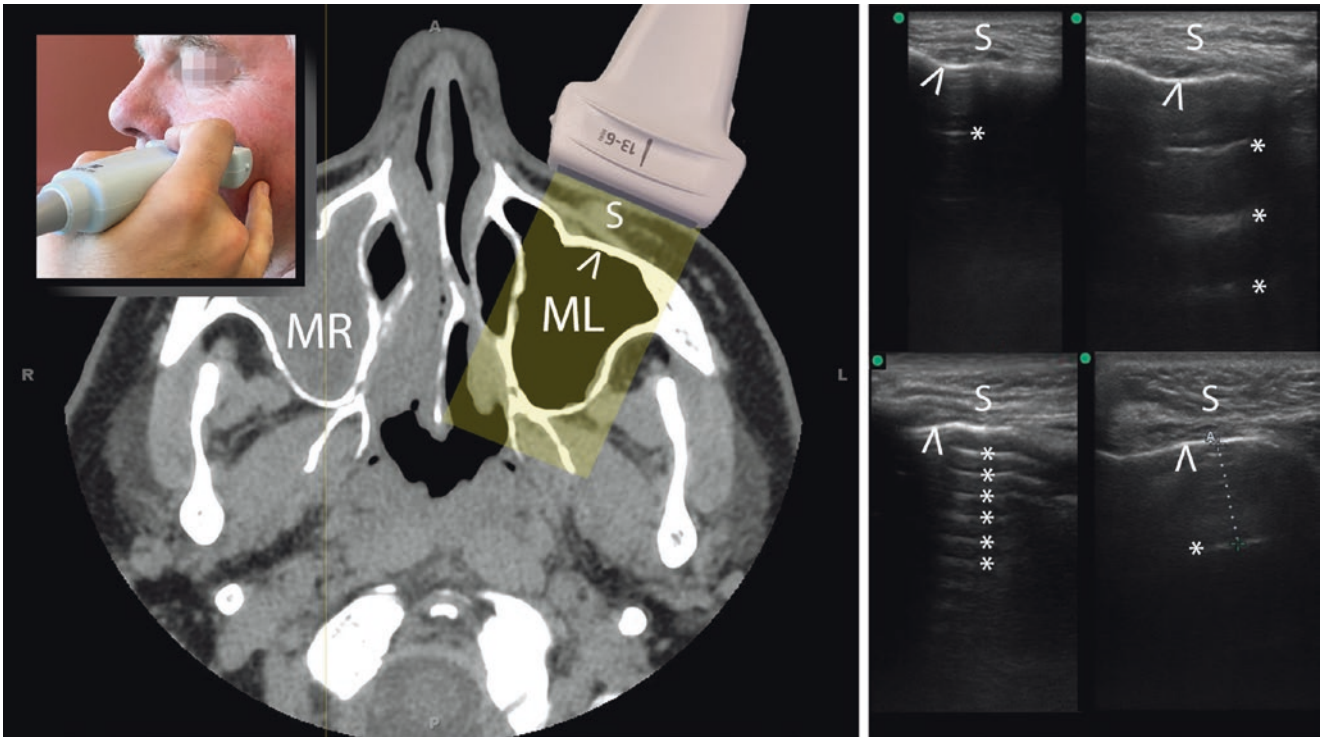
Normal left maxillary sinus (ML) transverse ultrasound variation with CT reference: Only the anterior wall (^) resulting in partial acoustic shadowing with minimal reverberation artifact (*) may be seen (upper left ultrasound image), but reverberation artifact (similar to “A-lines” in normal lung) may be more prominent (upper right, lower
